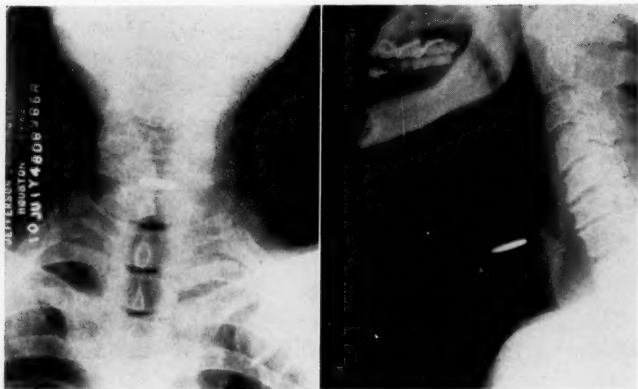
X-ray films showing in A P and lateral views the unusual position assumed by a dime. It had been lodged between the true and false cords for six days.
